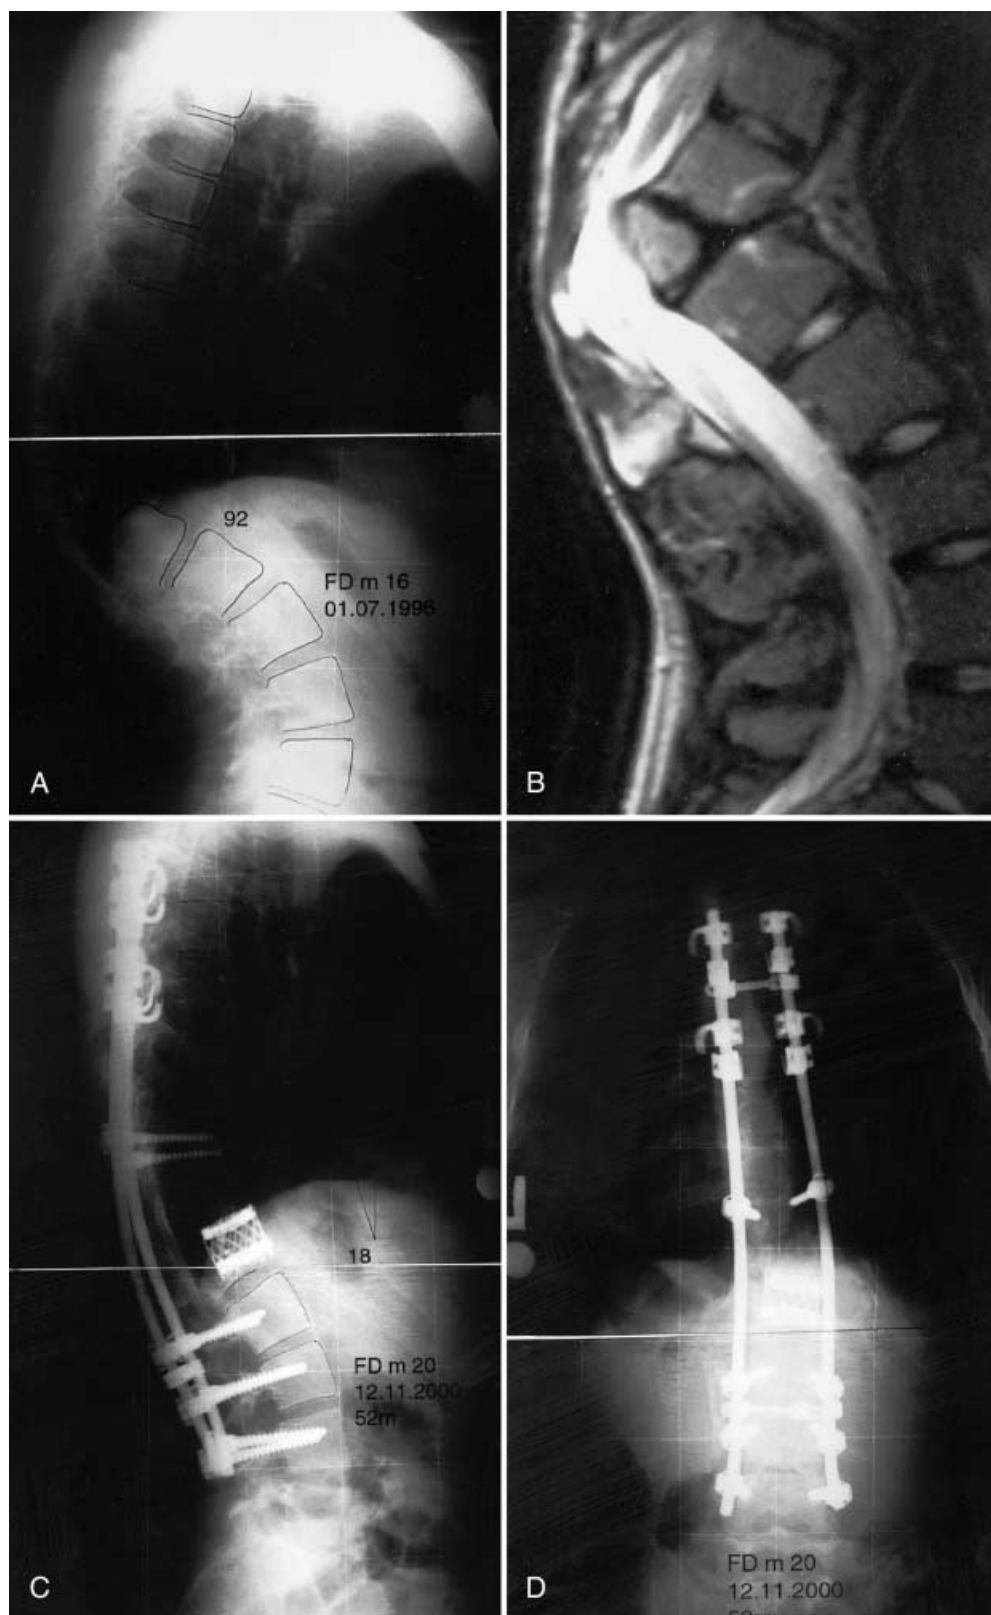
a Preoperative lateral X-ray of patient no. 7 caused by tuberculous spondylitis sequela. b Preoperative magnetic resonance imaging (MRI) of the same patient in the sagittal plane displaying
